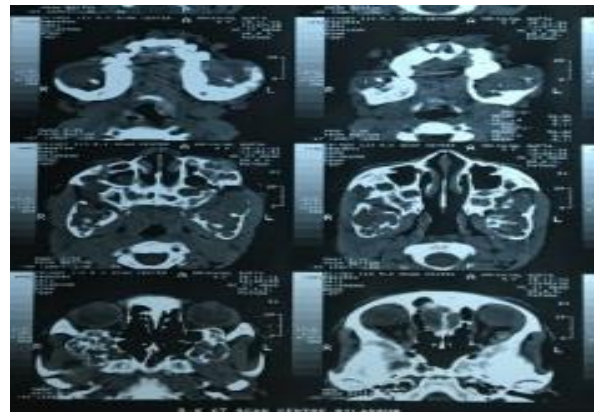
Axial CT Scan slices.
